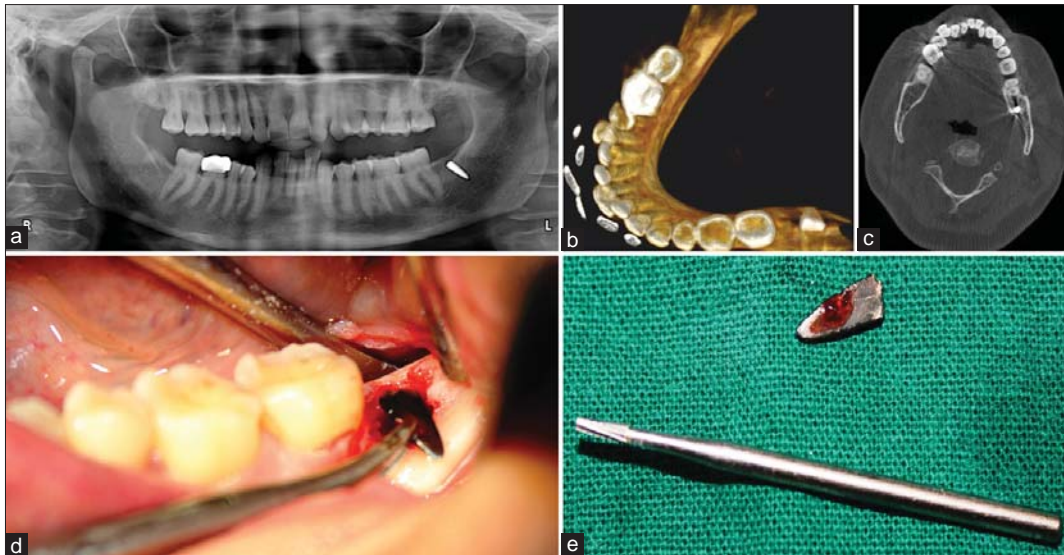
(a) Orthopantomogram of the patient with tip in place, (b) 3D formatted image of the root tip from CBCT, (c) Axial View in CBCT. Note the horizontal split, (d) Clinical Photo. Note the blackish tissue, (e) The size of the elevator tip
